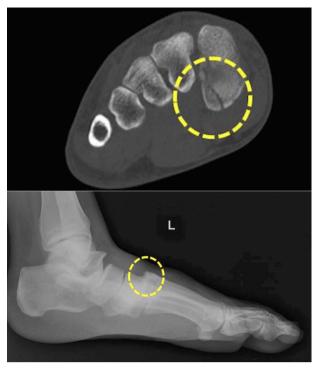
Top: fleck sign on CT is indicating avulsion type injury to the second metatarsal base or medial cuneiform. Bottom: dorsal displacement on lateral plain film.
